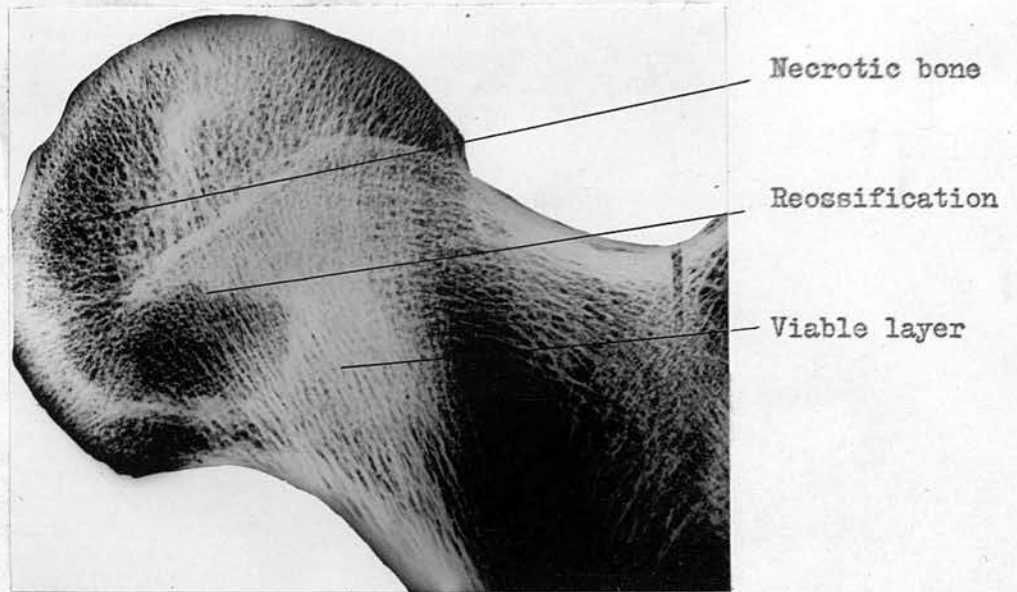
(d) - Radiograph of excised head of femur, same case as Fig. 73(a), showing dense zone forming a rough curvi-linear layer.
